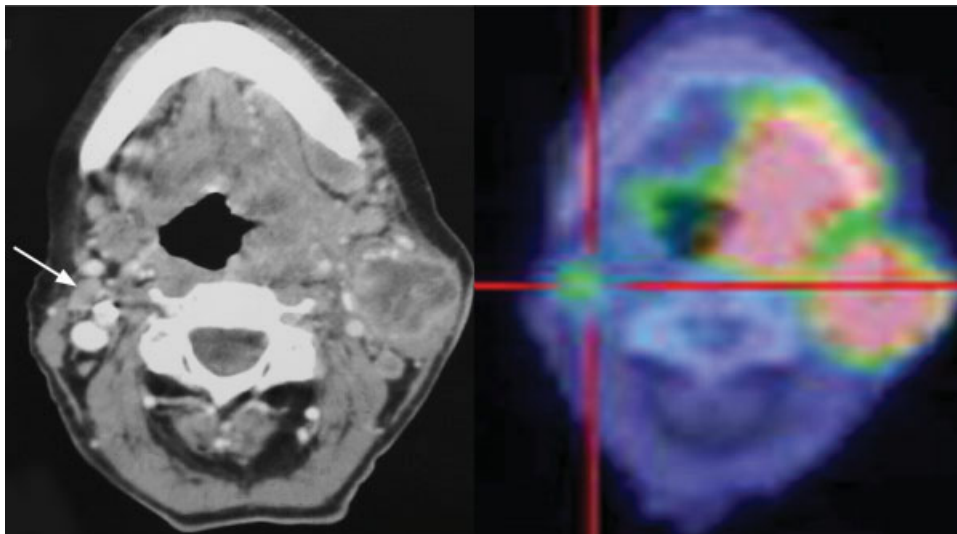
In this patient, conventional staging showed a T4N2b SCC L oropharynx. The R neck level II neck node (arrow) was not considered suspicious by CT criteria. PET/CT identified uptake at this site, upstaging the disease to N2c. This resulted in an alteration in technique from a conformal parotid sparing approach to parallel opposed fields.
